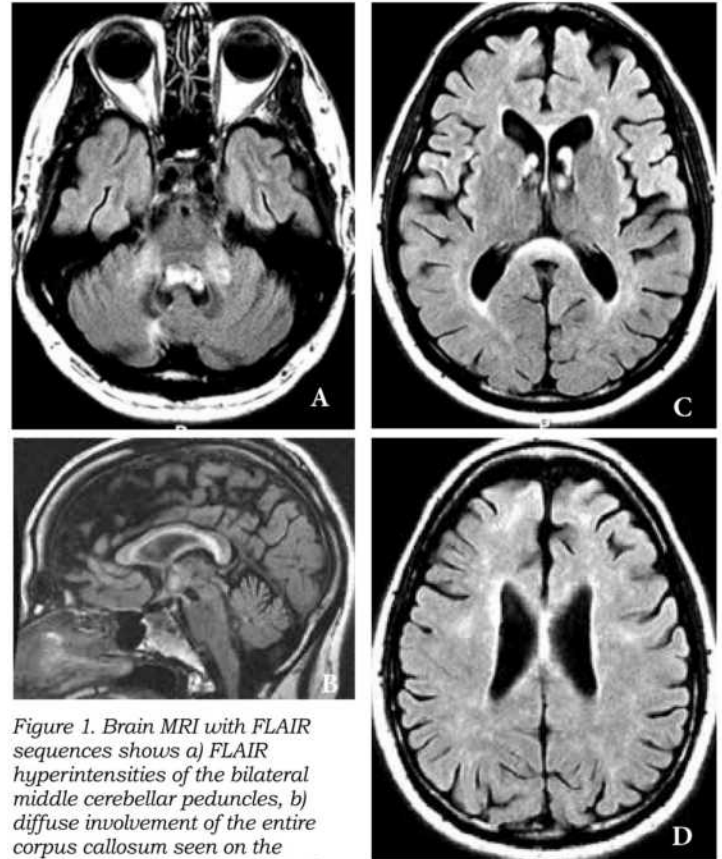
Brain MRI with FLAIR sequences shows a) FLAIR hyperintensities of the bilateral middle cerebellar peduncles, b) diffuse involvement of the entire corpus callosum seen on the midsagittal section, c) the anterior portion and splenium of the corpus callosum with d) more diffuse superior subcortical white matter involvement.
